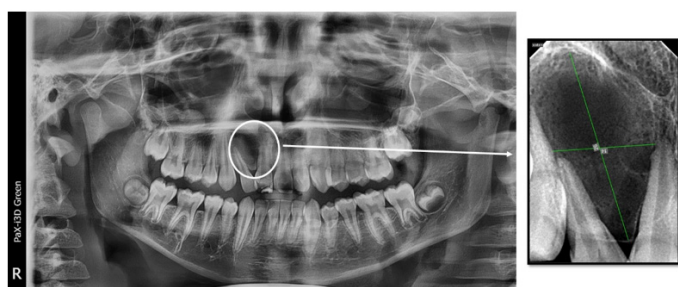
A panoramic radiograph shows tilted roots of the right lateral incisor due to pressure of the periapical lesion (circle). A preapical radiograph shows a large periapical lesion (14x26mm) with diverged roots of related teeth (#12 and 11).
